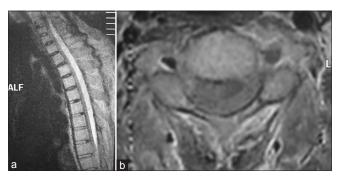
(a) Sagittal magnetic resonance imaging of cervicothoracic spine showing the extradural hematoma dorsal to the cord. (b) Axial magnetic resonance imaging scan showing the extradural hematoma
